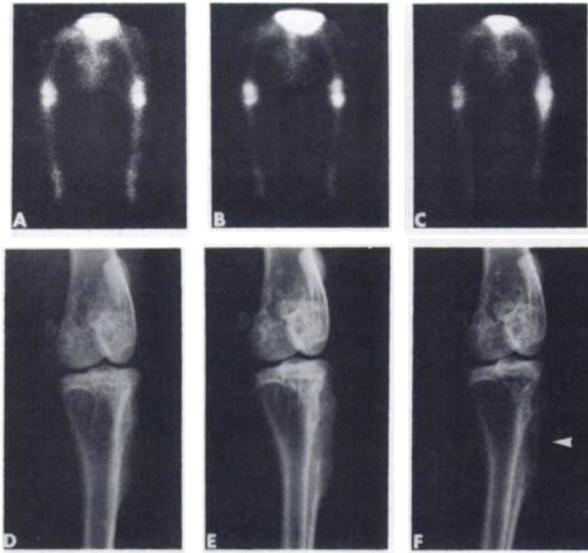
Poorly differentiated osteosarcoma developing in left hind leg after irradiation with 1756-rad single dose. Supine TcPPi images at 9.5 (A), 10.5 (B), and 12 (C) mo, and radiographs at 9 (D), 10.5 (E), and 12 (F) mo after irradiation. Tumor first seen on images at 9.5 mo (A) by a focal increase of TcPPi in proximal tibia and subsequently on radiographs at 12 mo (F) in anterolateral aspect of proximal tibia as a subtle radiolucent lesion (arrow). Progression of tumor growth evident on later images.
